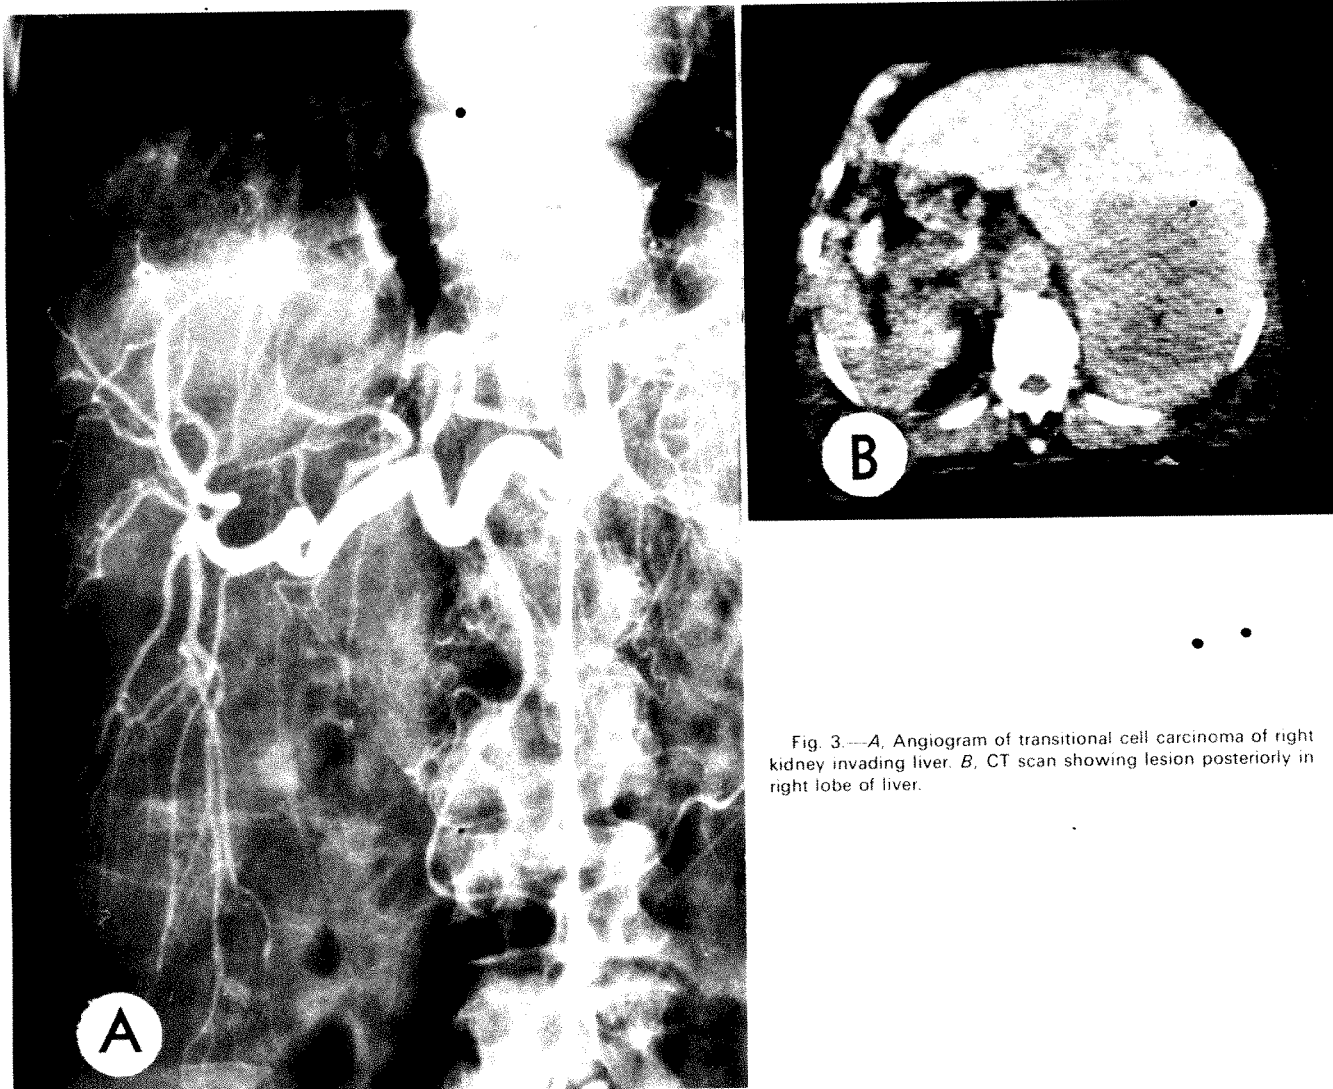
A, Angiogram of transitional cell carcinoma of right kidney invading liver. B, CT scan showing lesion posteriorly in right lobe of liver.
